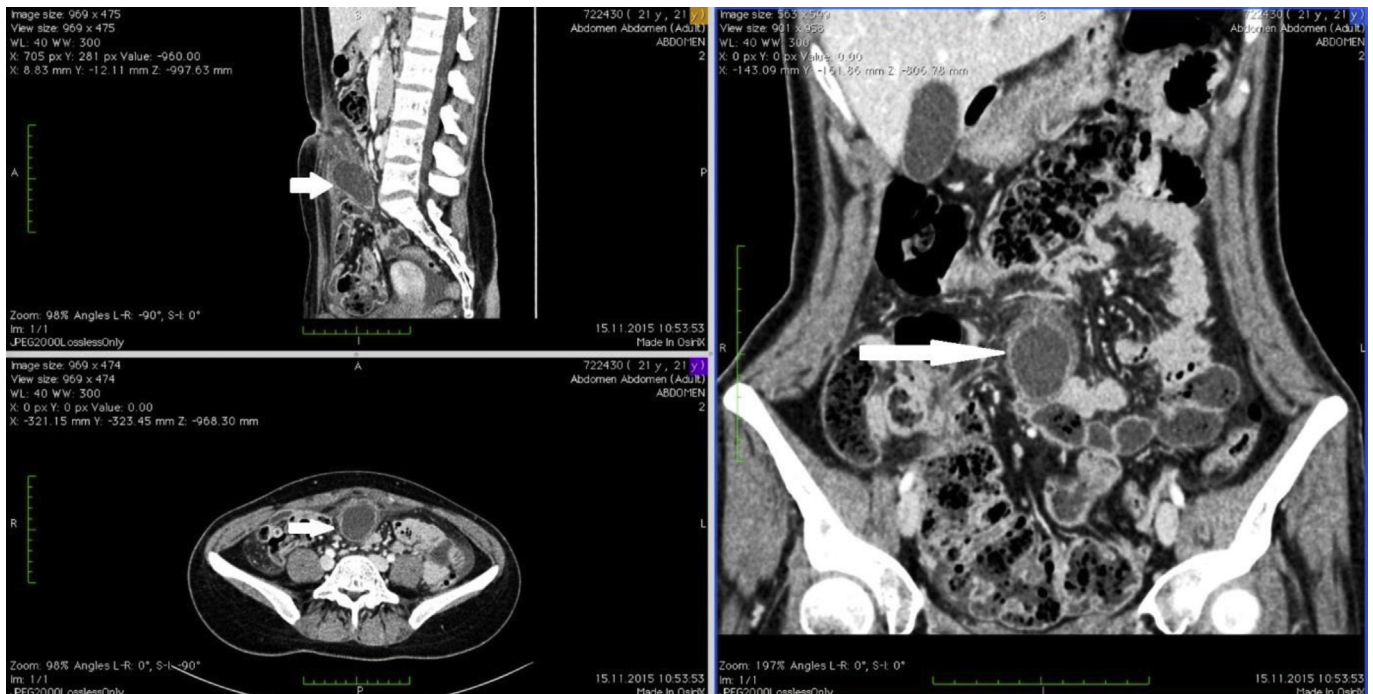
CT imagine: subumbilical region presence of abscess formation.
